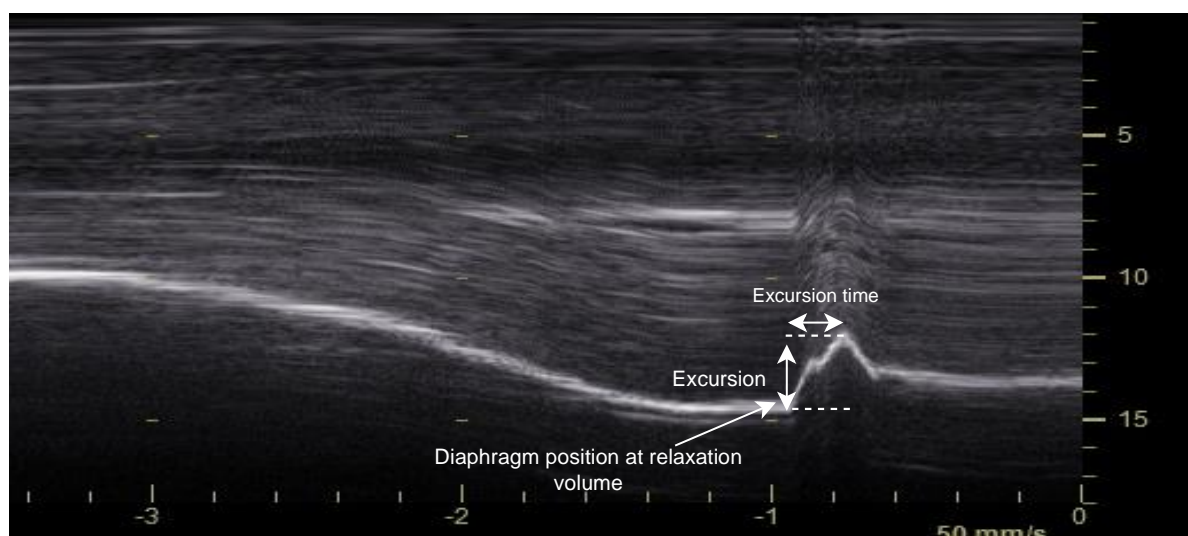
M-mode and AM-mode ultrasound of crural diaphragm (bright hyperechoic line). Craniocaudal excursion and excursion time were measured as indicated by arrows. This example shows paired (10 Hz) twitch excursion of 3.0 cm in female participant.
